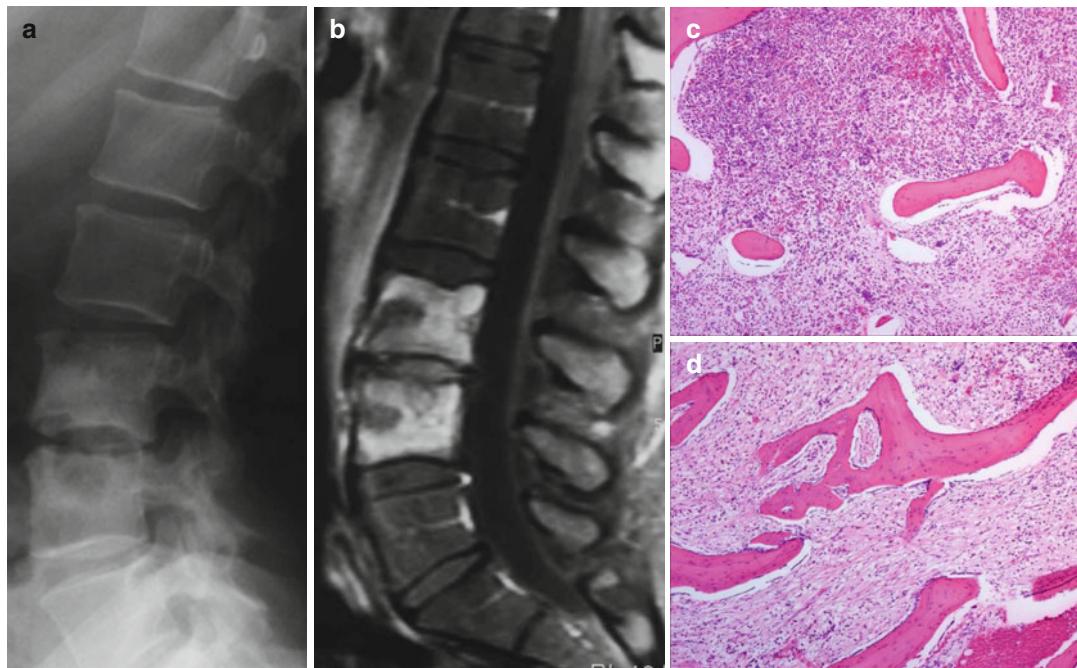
A 13-year-old girl with chronic sclerosing spondylodiscitis of L3/4. (a) Lateral spine radiograph shows endplate sclerosis L4/5 with (b) pronounced Gd enhancement throughout the intervertebral disk and vertebrae.
